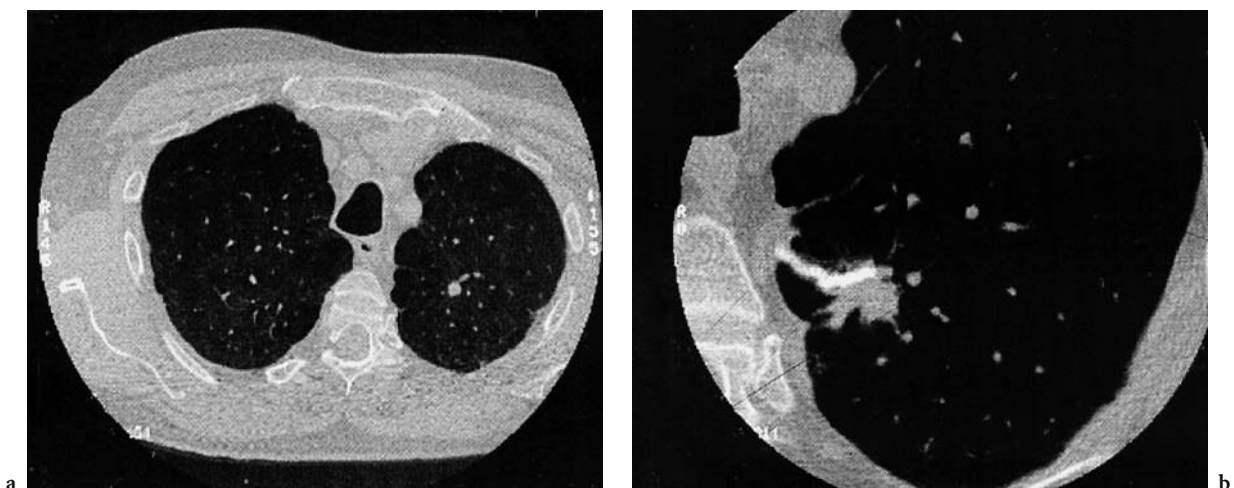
a High resolution CT image of a nodule prior to attempted thoracoscopic resection. b High resolution CT image post attempted thoracoscopic resection shows the nodule still present adjacent to the suture line
